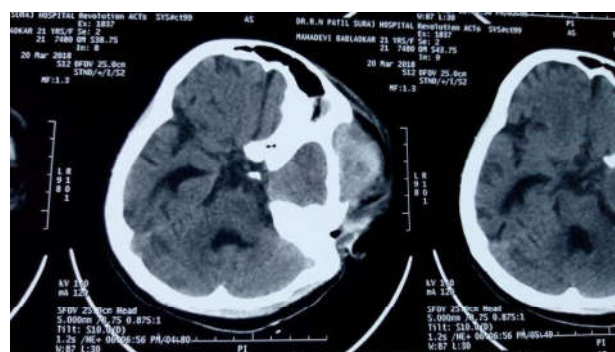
CT imaging showing AV malformation.
